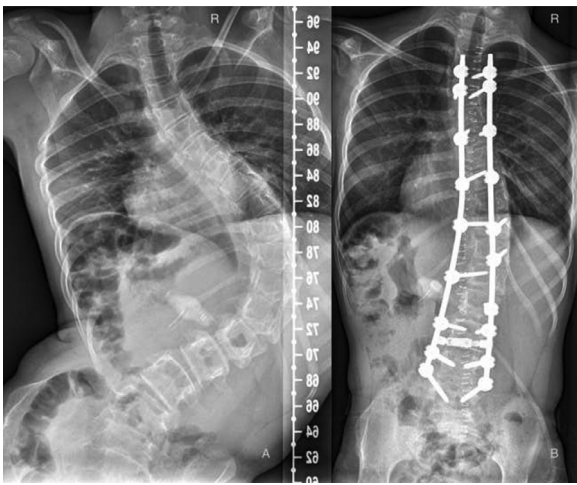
A: 13-year-old patient with a cerebral palsy related scoliosis. Preoperative whole spine radiograph with a scoliotic deformity of 113° Cobb angle between Th8 and L3. Pelvic obliquity (Maloney) of 25°
